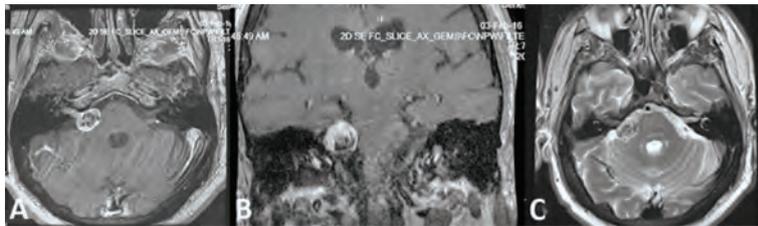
Initial T1-weighted post-contrast MRI of the 58-year-old patient (Case 2). (A) Axial, (B) coronal, and (C) T2 axial views show right-sided VS. The tumor was followed up.
